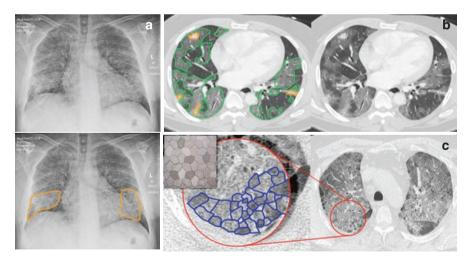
Annotated examples of COVID-19 scans. (a) Chest X-ray (CXR) with ground-glass opacification in both lungs and consolidation (outlined in orange). (b) A CT scan that shows ground-glass opacification (green) and consolidation (orange). (c) A CT scan that indicates severe COVID-19 with a crazy-paving pattern. (Images from the NCCID [4], and inset from [5])
